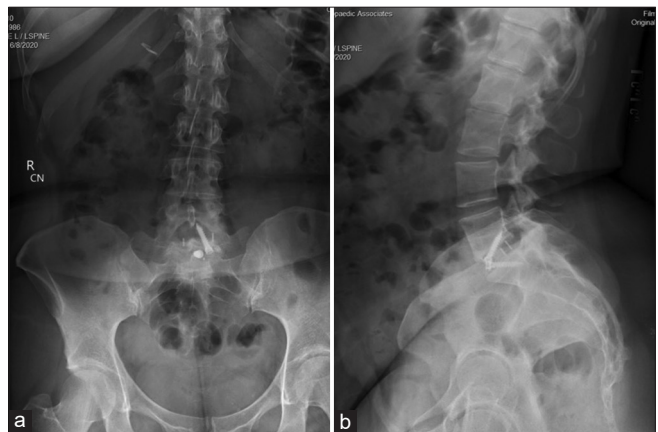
(a) Postoperative anteroposterior radiograph of the lumbar spine demonstrating anteriorly placed interbody cage at the L5-S1 level. (b) Postoperative lateral radiograph of the lumbar spine demonstrating anteriorly placed interbody cage at the L5-S1 level.
